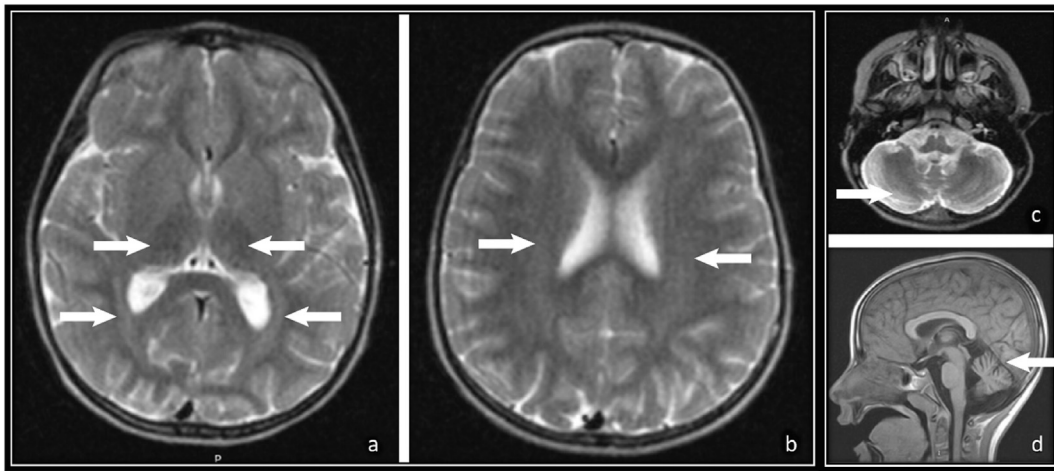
Patient 6 – T2-weighted axial sections (a, b, c) and T1-weighted sagittal section (d) from an MRI scan taken 1 year after the onset of symptoms. Linear hyperintensity of central white matter is highlighted (a, b), and thalamic hypointensity can also be seen (a). Mild cerebellar atrophy is demonstrated (c, d).
